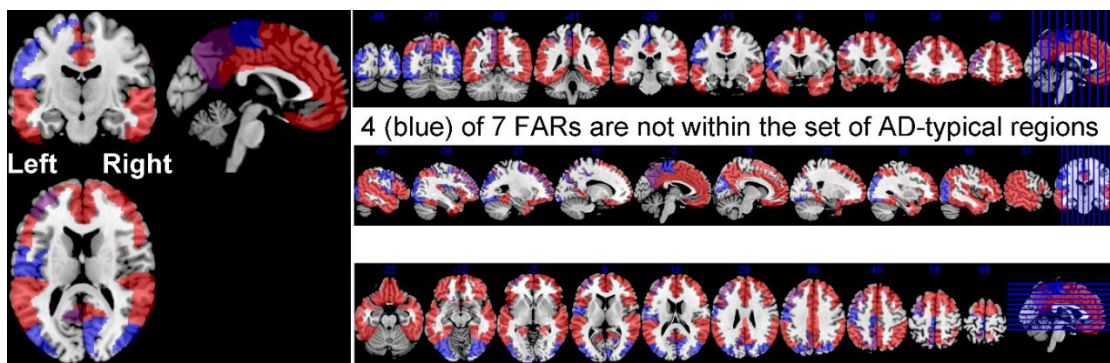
Seven fast accumulating regions (FARs) in phase 3 (purple plus blue) and AD-typical regions (red) are overlaid on a standard MRI template in MNI space. Purple and blue denote that FAR is within (3 regions) and outside (4 regions) the set of AD-typical regions, respectively.
